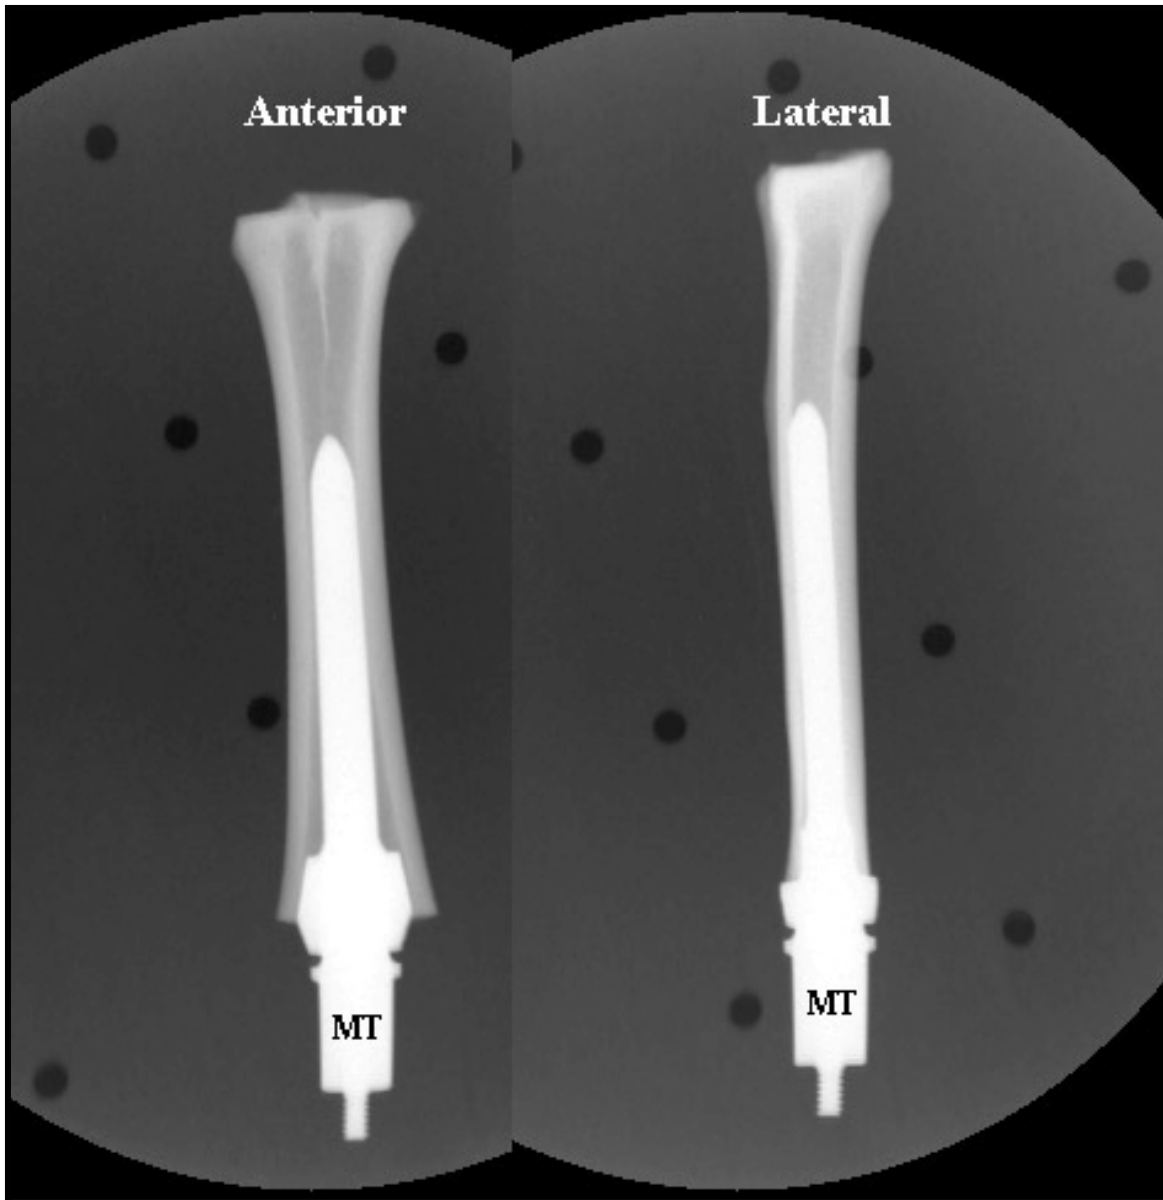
Anterior and Lateral radiographs of metacarpal III with metal implants inserted. MT = Morse Tapered post for prosthetic attachment.
